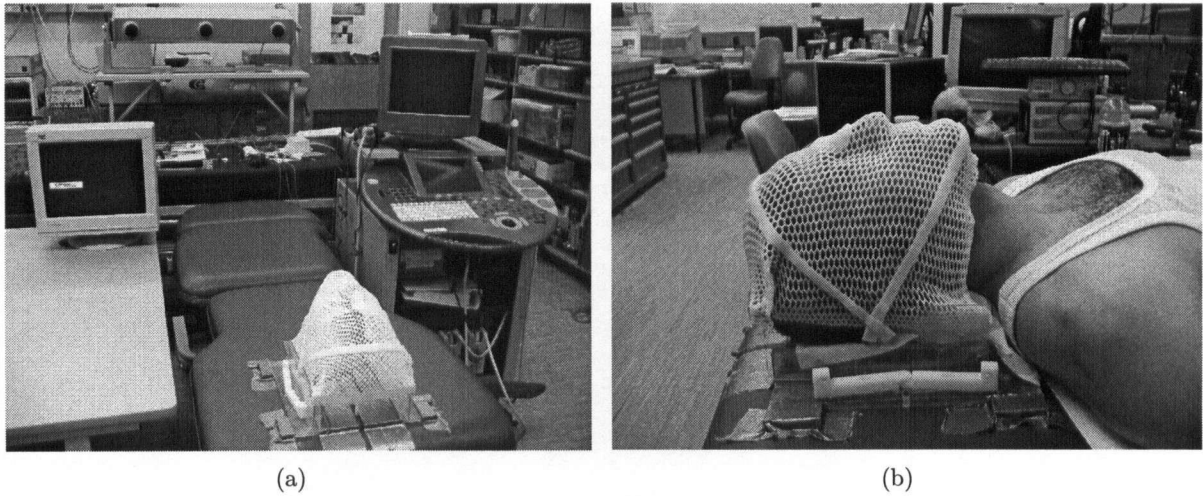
Experimental set-up for acquiring ultrasound images from the neck of a volunteer. The couch is positioned in front of the OPTOTRAK and beside the Voluson 730 ultrasound machine (a). The subject is immobilised by a thermoplastic mask moulded to the contour of his face and clamped to a base plate during image acquisition (b). Note that in this image the clamp was released. The lower portion of the neck was left exposed to allow access by the ultrasound probe.
